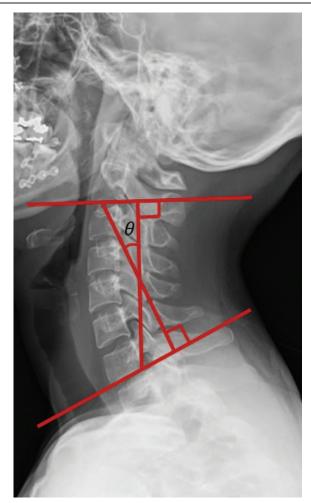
A lateral cervical X-ray in the neutral position showing a Cobb angle measurement between the lower border of the C2 body and the upper border of the C7 body.
